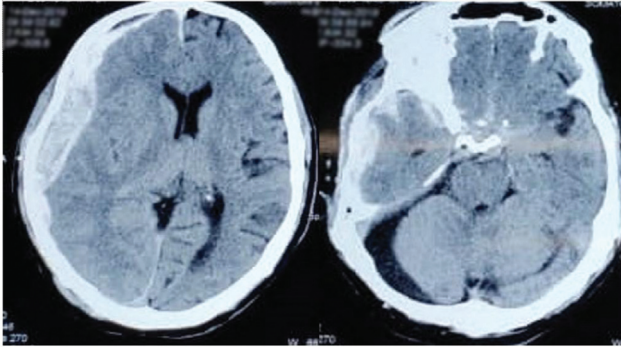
Computed tomography scan done after 1 hour of trauma.
